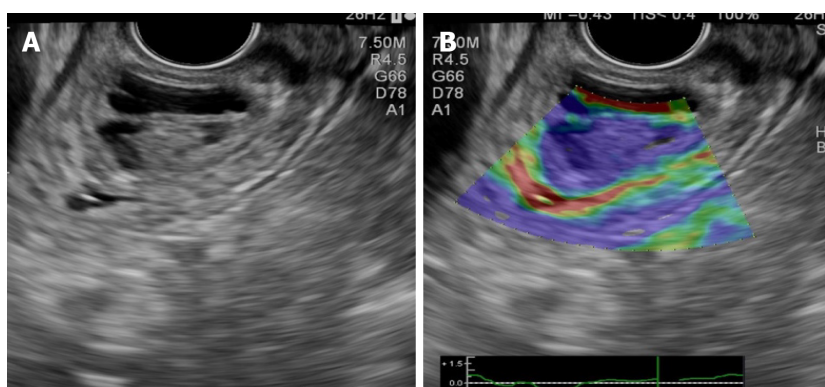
Endoscopic ultrasound of the distal common bile duct. A: Small non-invasive tumoral mass (distal cholangiocarcinoma); B: Elastography: Blue color of the tumor (hard stiffness).
